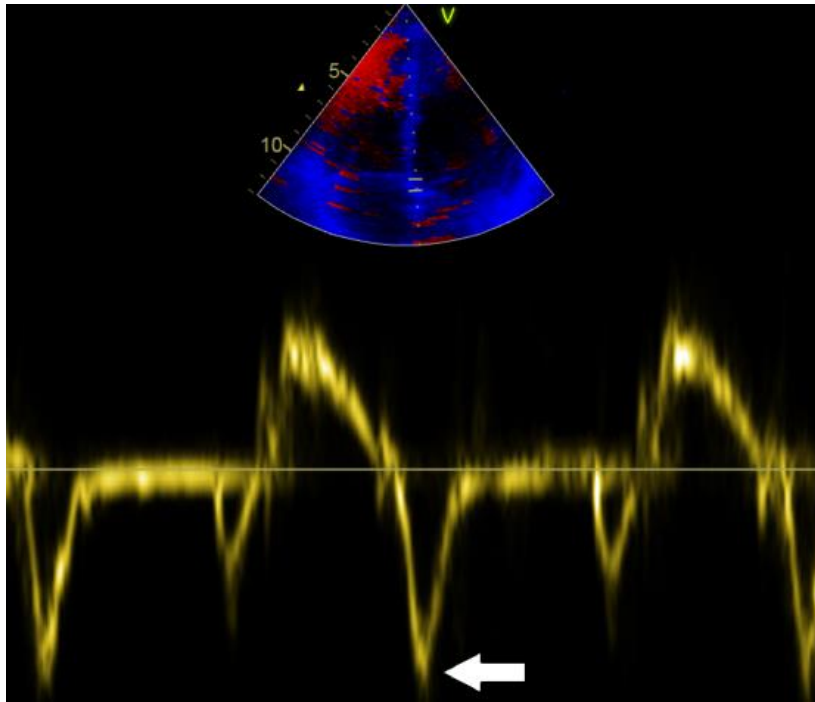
Tissue Doppler measurements of mitral annular displacement velocity (e'). Arrow marking e' value.
